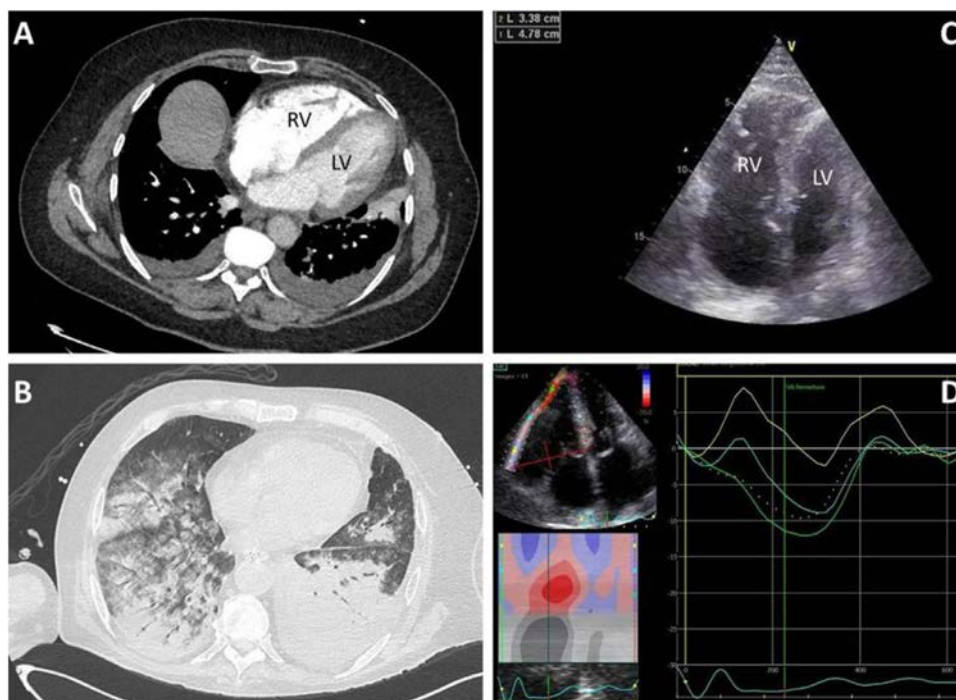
COVID-19 pattern and acute respiratory distress syndrome. (A) Right ventricular dilation on computed tomography. (B) Severe pulmonary involvement detected by computed tomography. (C) Echocardiographic right ventricular dilation (apical 4-chamber view). (D) Depressed longitudinal right ventricular strain.
